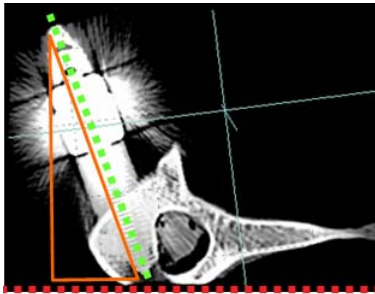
Experimental Result: CT scan image
